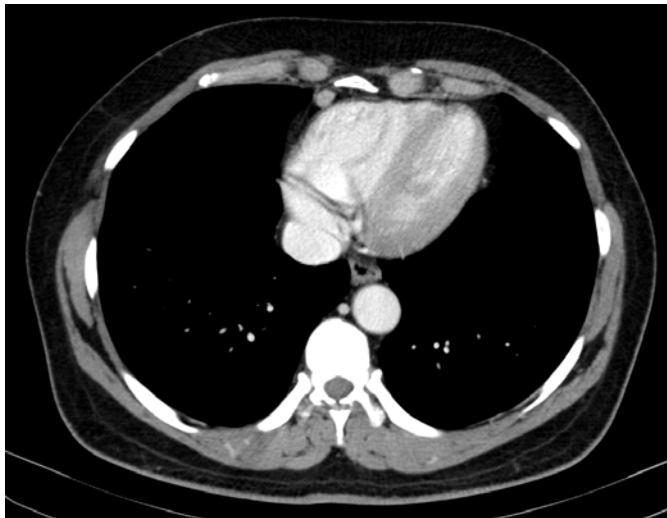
Transverse i.v. contrast-enhanced CT in the venous phase showing a lymph node metastasis from a small intestinal NET in the right lower-ventral thorax adjacent to the heart (arrow).
